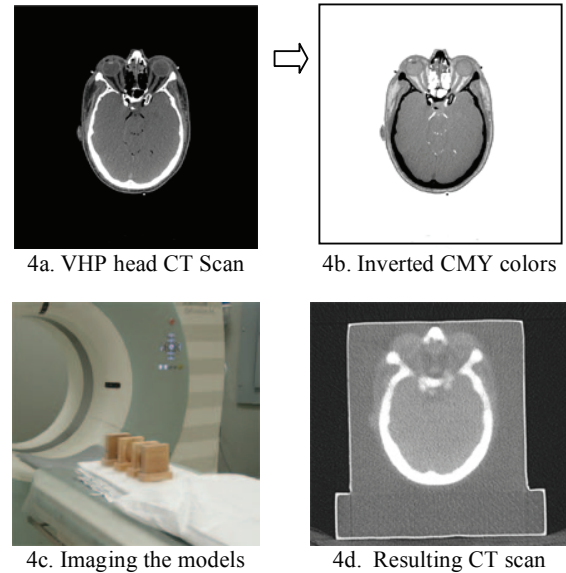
Description and results of the first demonstration case. A slice from a head CT scan (4a) is inverted (4b) and extruded into a 3D model, printed and scanned (4c). The resulting image (4d) clearly shows hard and soft tissue matching the original data.
